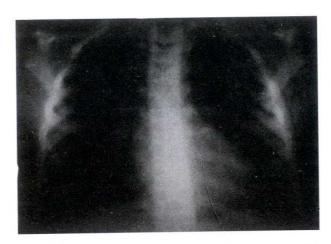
P-A x-ray of the lungs, with no detectable pathology.
